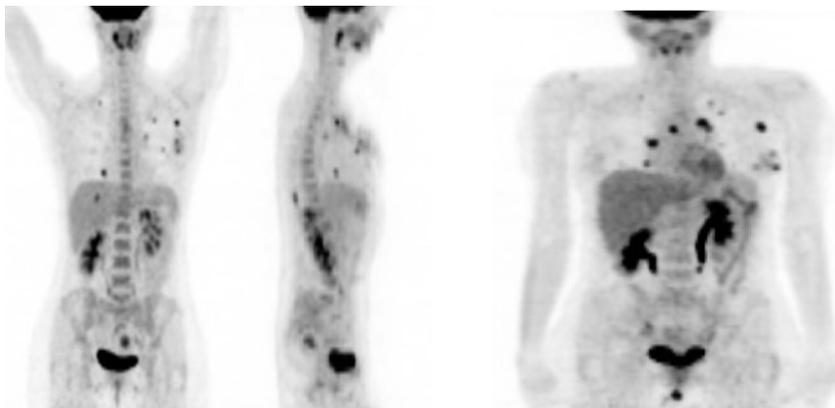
PET-CT at diagnosis
